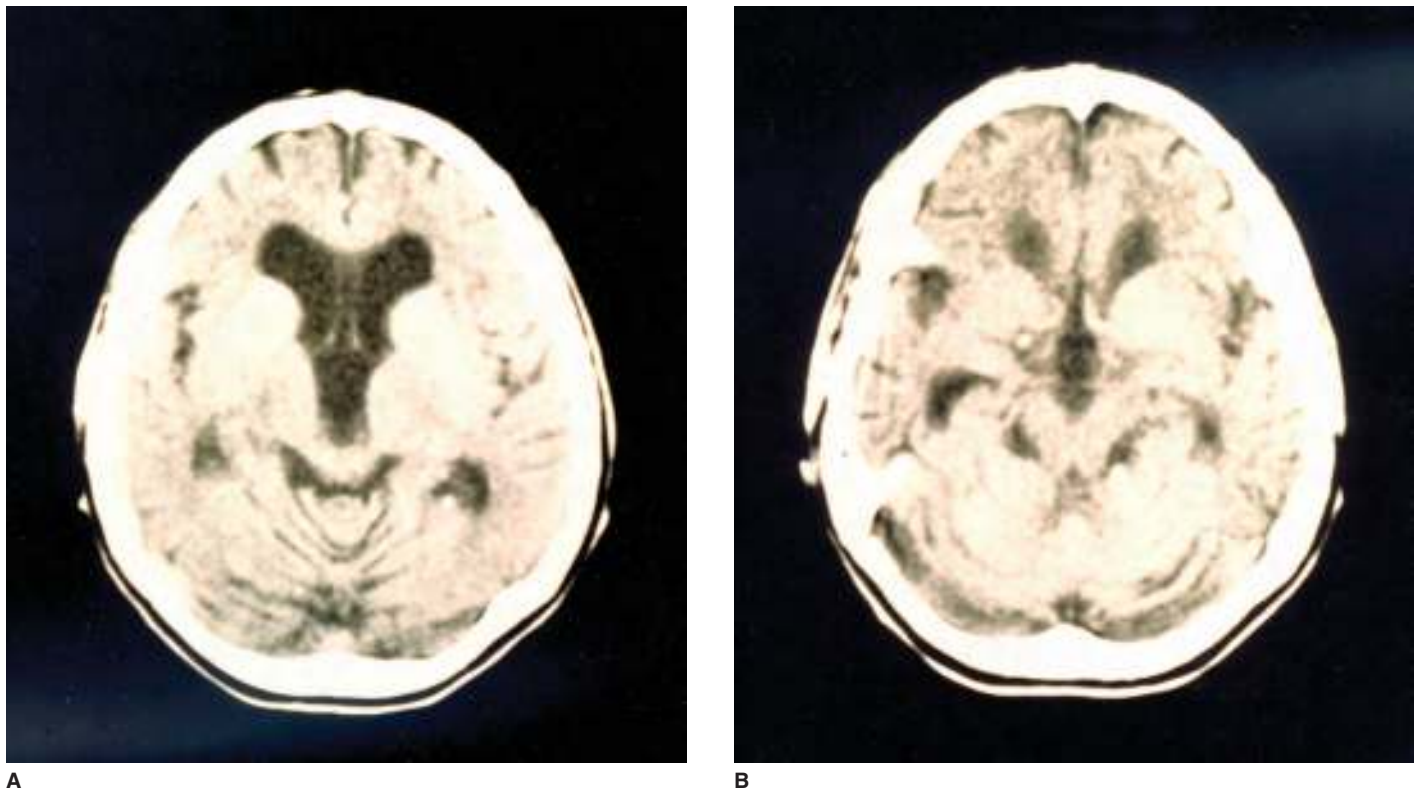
Head CT of a patient with hydrocephalus. A. The ventricles are enlarged with effacement. B. Pronounced temporal horns.
